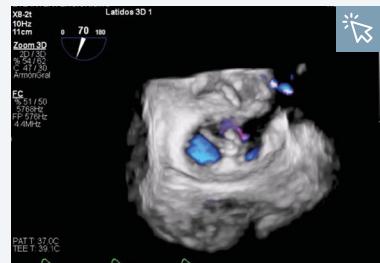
Final result in three-dimensional echocardiography.²⁷
